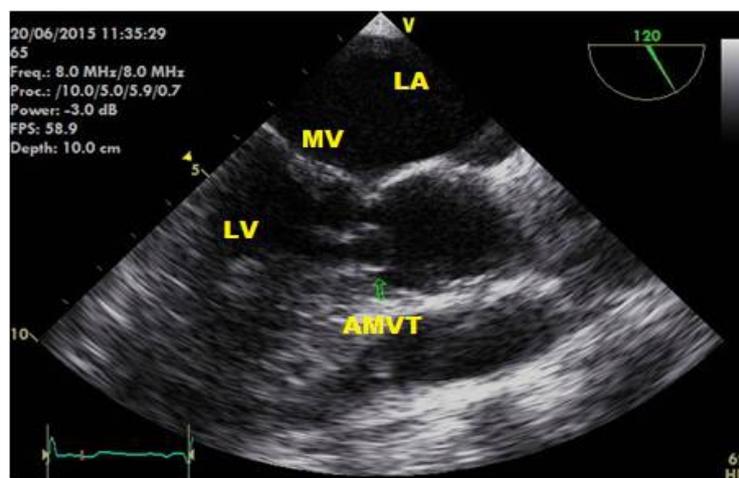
Two-dimensional transesophageal echocardiogram at 120° shows AMVT (green arrow) in the left ventricular outflow tract.
